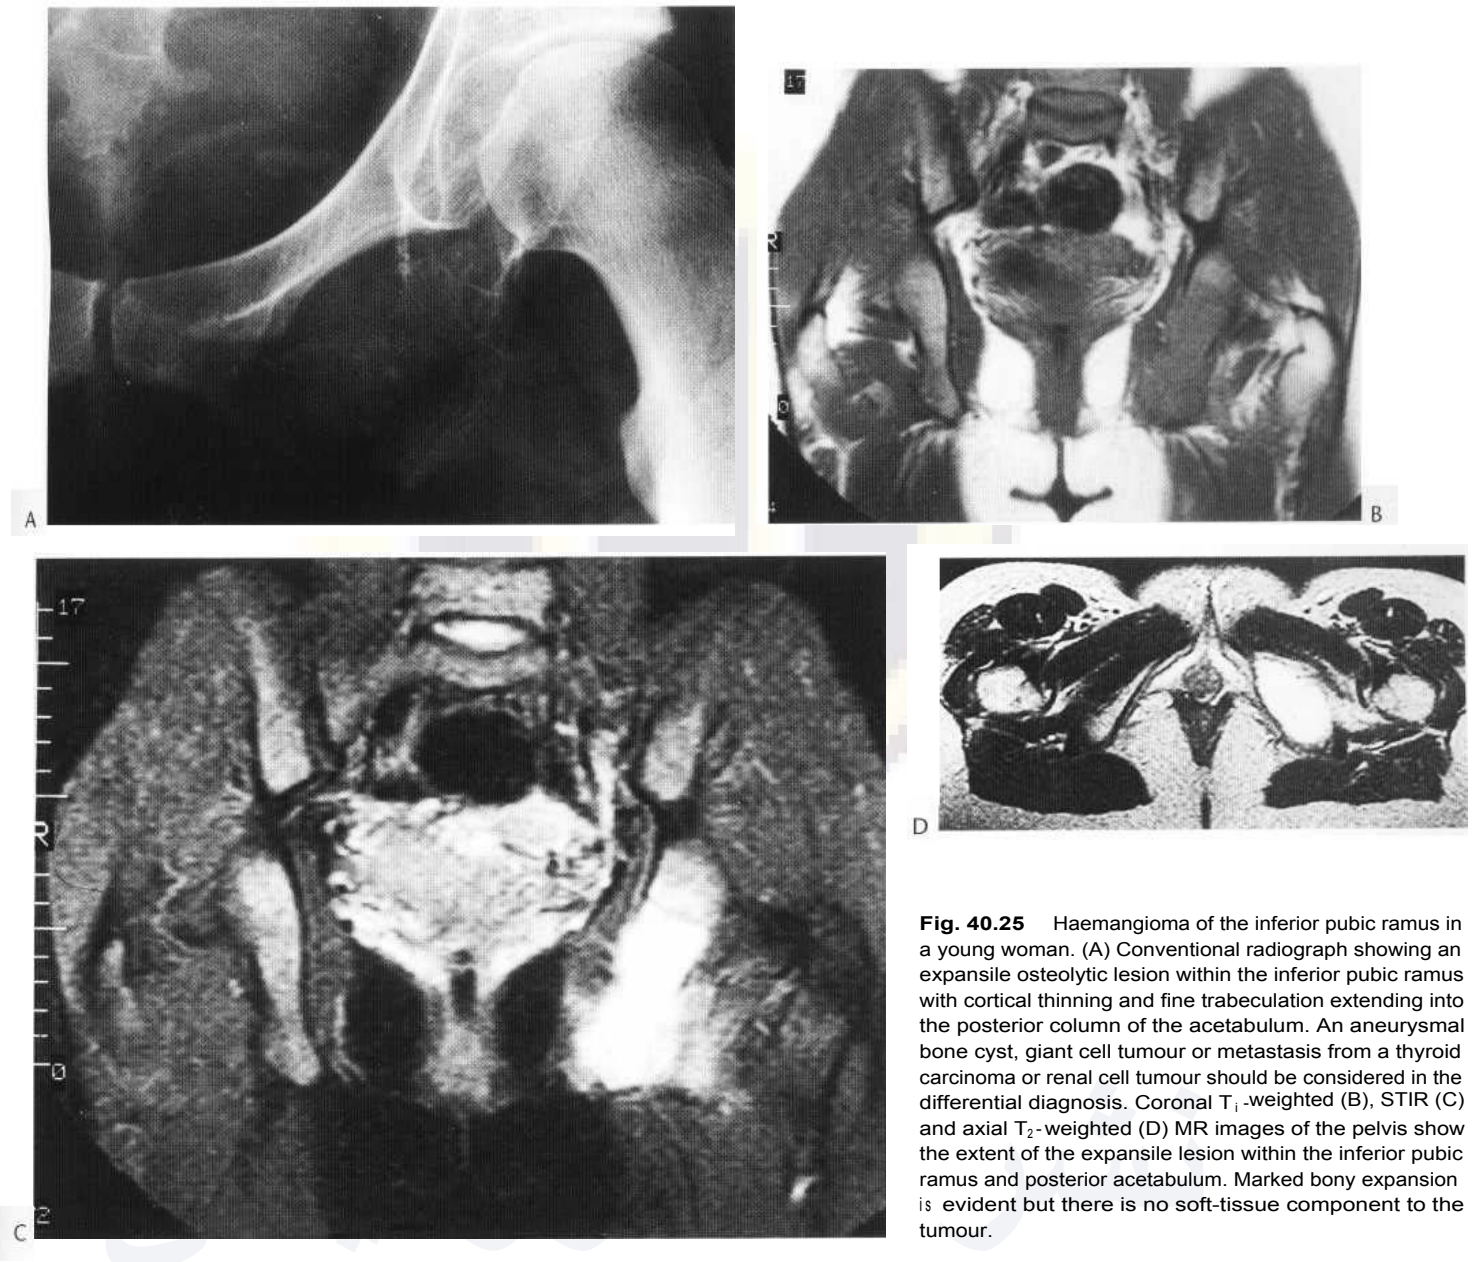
Haemangioma of the inferior pubic ramus in a young woman. (A) Conventional radiograph showing an expansile osteolytic lesion within the inferior pubic ramus with cortical thinning and fine trabeculation extending into the posterior column of the acetabulum. An aneurysmal bone cyst, giant cell tumour or metastasis from a thyroid carcinoma or renal cell tumour should be considered in the differential diagnosis. Coronal T₁-weighted (B), STIR (C) and axial T₂-weighted (D) MR images of the pelvis show the extent of the expansile lesion within the inferior pubic ramus and posterior acetabulum. Marked bony expansion is evident but there is no soft-tissue component to the tumour.
